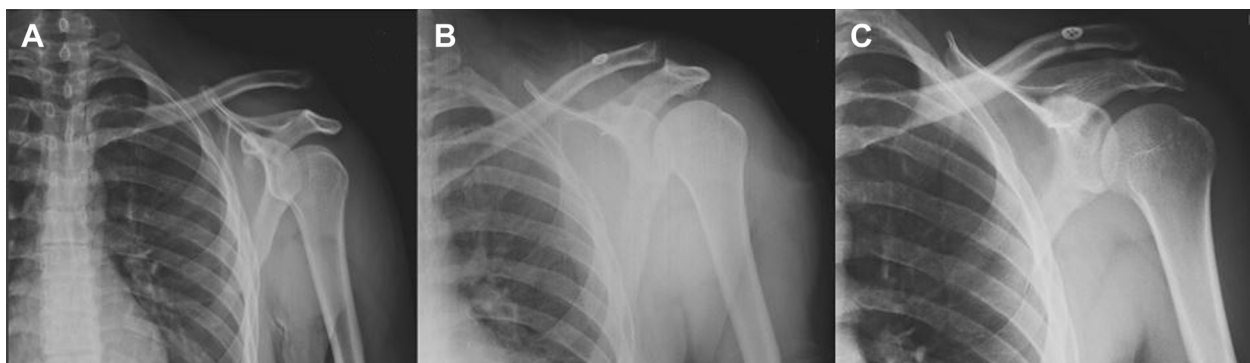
(A-C) Radiographic projections in left shoulder of patient classified as “failed reduction.”
